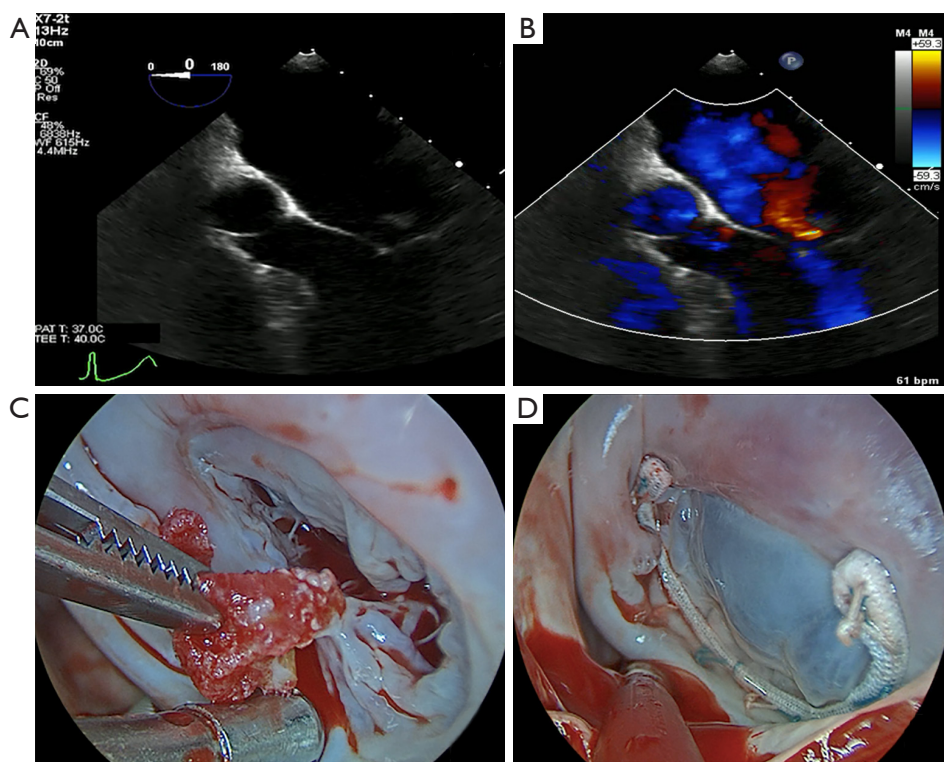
Trans-esophageal echocardiogram showing: (A) lobulated mass at the level of the free edge of the posterior mitral valve leaflet and (B) moderate central mitral valve jet. (C) Intraoperative finding of a left atrial mass with a small pedicle arising from free edge of the posterior leaflet of the mitral valve; (D) mitral valve annuloplasty by means of incomplete semi-rigid band.
